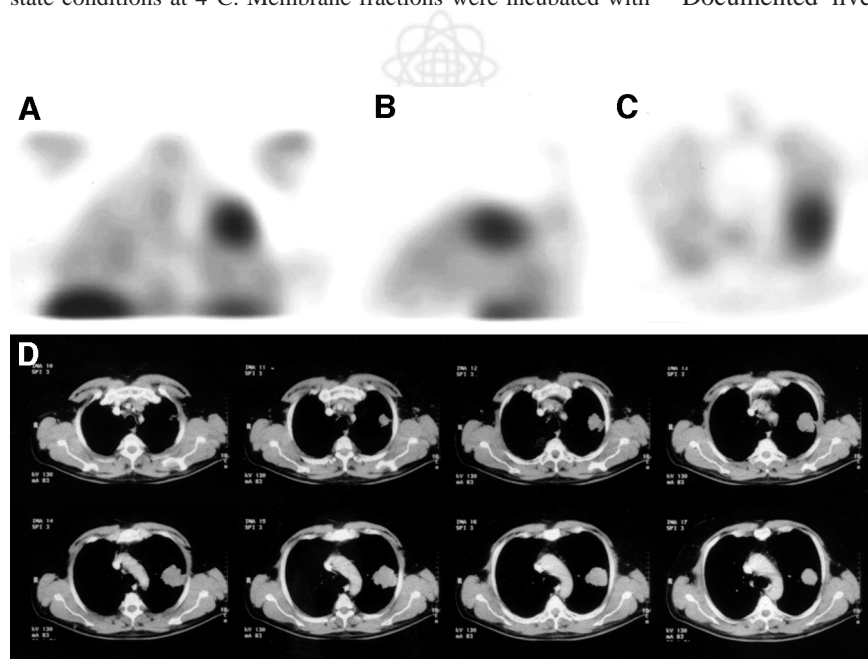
Coronal (A), sagittal (B), and axial (C) views of ^{111}In -DOTA-LAN SPECT study of patient with squamous cell carcinoma of left lung. (D) Corresponding CT study.
